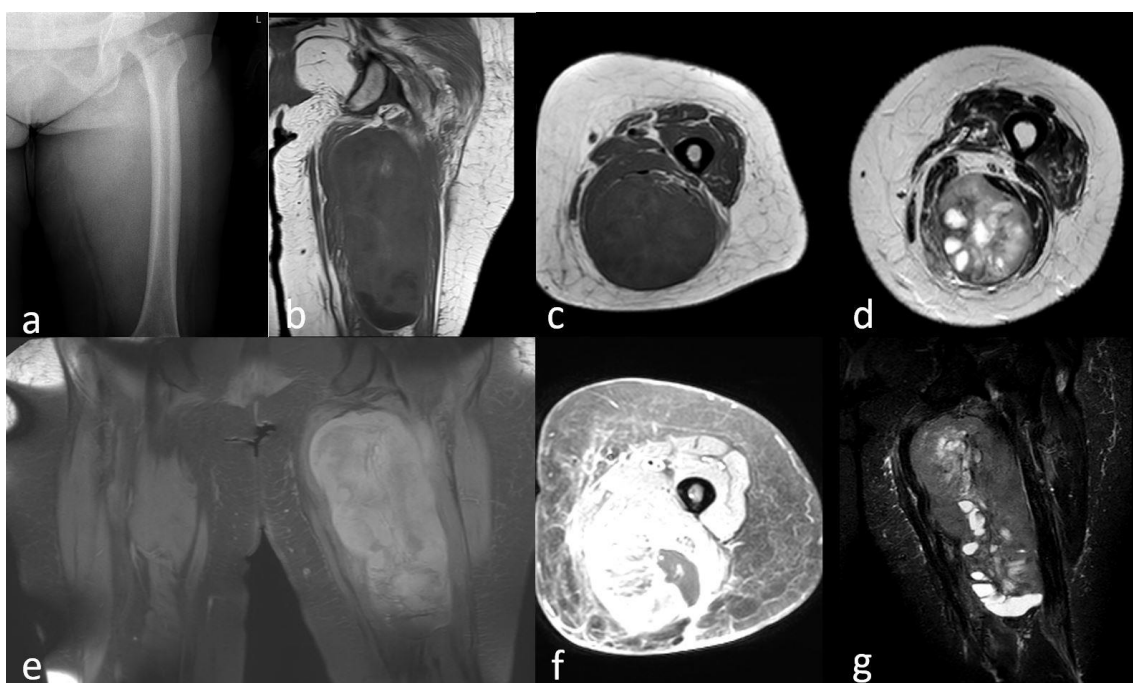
A 63-year old female patient presented with complaints of swelling in the posterior of the left thigh. (a) Increased soft tissue density in the thigh posterior region on the plain radiograph. There was no calcified or ossified lesion and no pathology in the bone tissue. (b, c) Heterogeneous hypointense lesion localized in a relatively well defined smooth muscle with deep location on MR, T1W images, (d) Heterogeneous appearance with a hyperintense signal especially in the central region, (e, g) Heterogeneous hyperintensity on STIR images, (f) contrast-enhanced central hypointense signal-dense lesion with intense contrast enhancement.
